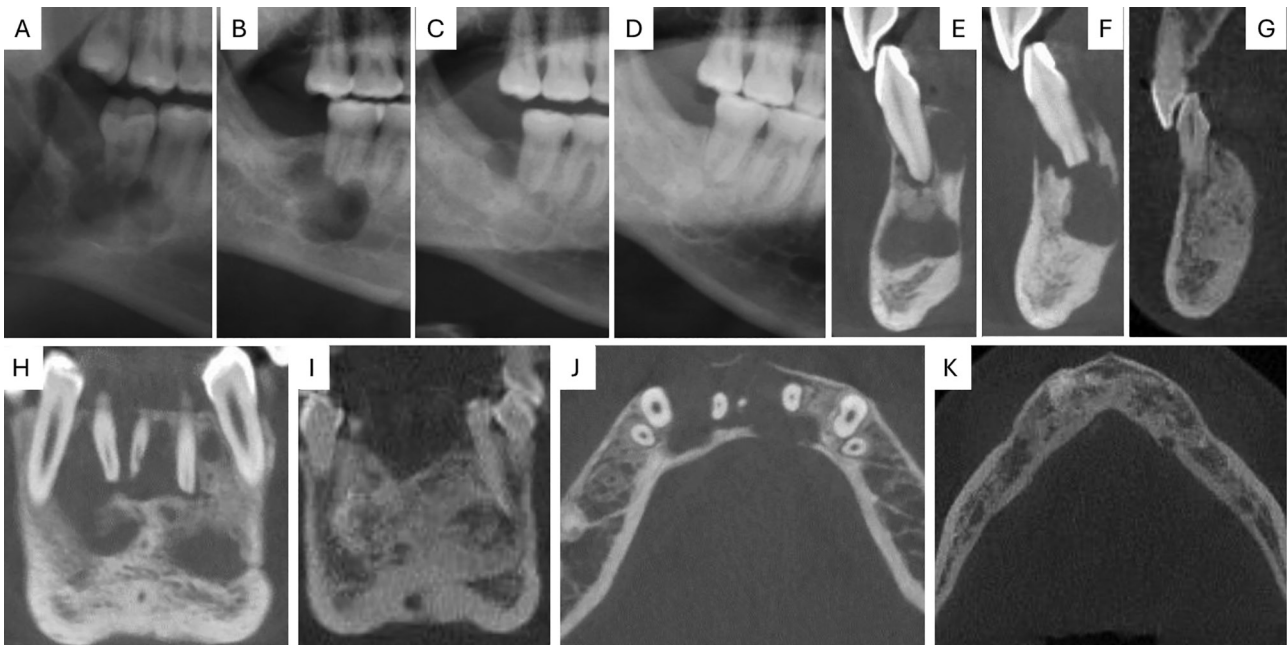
Radiologic course of treated central giant cell granulomas (CGCG) in 2 patients with neurofibromatosis type 1 (NF1). Case 1: A-D; Case 2: E-K. Case 1: (A) Extensive CGCG with bone defect from the mandibular ramus to the second molar of the right mandible. (B) Two years after initial treatment, a peri-radicular recurrence around the second molar became apparent. Another two years later, the image (C) showed a recurrence distal to the root of the second molar. (D) Almost five years after initial treatment, the bony defect had been ossified. Figures A-D are cropped images of orthopantomograms. Case 2: Figures E-G show the changes in the central lower incisor over time (sagittal section, CBCT). (E) Periradicular osteolysis, (F) loss of the root tip, (G) ten years later, the bone had ossified, and the tooth had a bony coating. (H) and (I) Coronal view of the mandibular front at the start of treatment (H), and after ten years (I) (ossification). (J) and (K) Axial view of the osteolysis, particularly of the anterior mandible, at the start of treatment (J), and 10 years later (K). During this treatment period, the patient retained a complete set of teeth in the anterior mandible. Figures E-K are cropped images of cone beam computed tomograms (CBCT).
